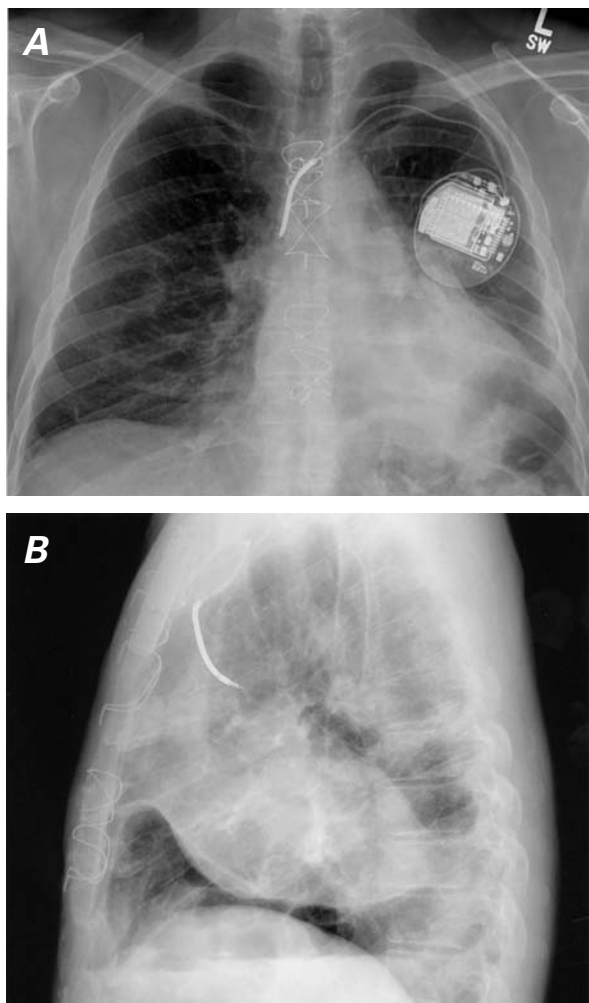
Chest radiograph on presentation demonstrates volume loss at the base of the left lung: A) anteroposterior view and B) lateral view.
